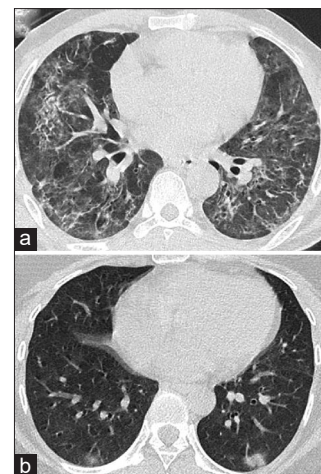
High-resolution computed tomography axial scans of two different male patients of 40 years of age admitted in the same time frame. (a) Diffuse ground-glass opacities in both lungs with computed tomography severity score of 22/25 inpatient have no vaccination history. (b) Subtle patchy ground-glass opacities with a computed tomography severity score of 5/25 in a patient with vaccination history
